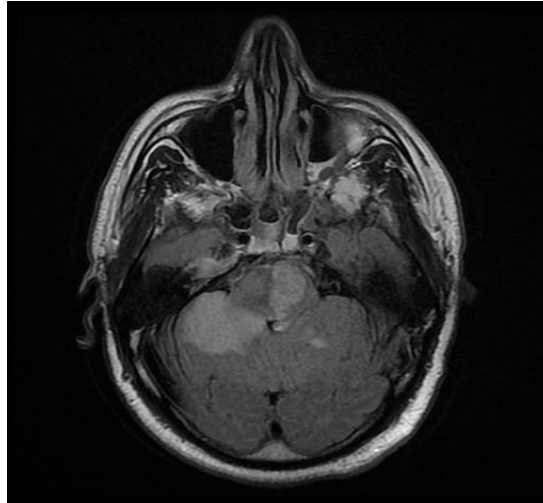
Brain MRI: Right cerebellar AVCI
